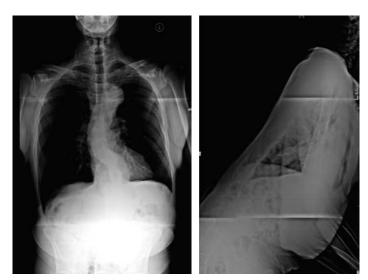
Pre operative radiographs. Note significant positive sagital balance.
